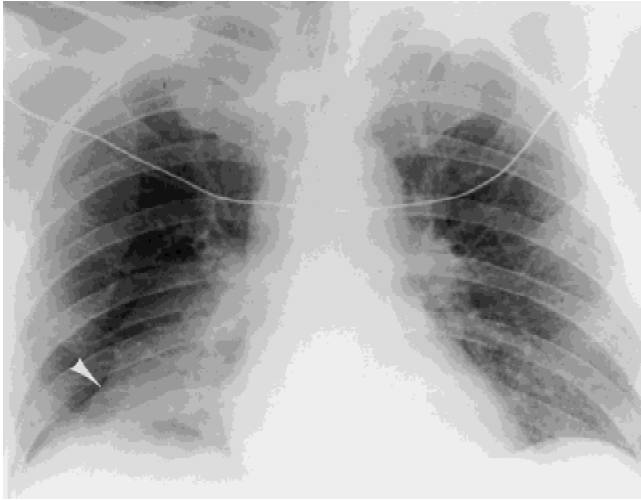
Day 1 in a patient with malignant peritoneal mesothelioma after intraperitoneal heated chemotherapy (IPHC) chest radiograph shows high density in the right lower lung outlined by an oblique fissure (arrowhead) indicating right-lower-lobe atelectasis.
